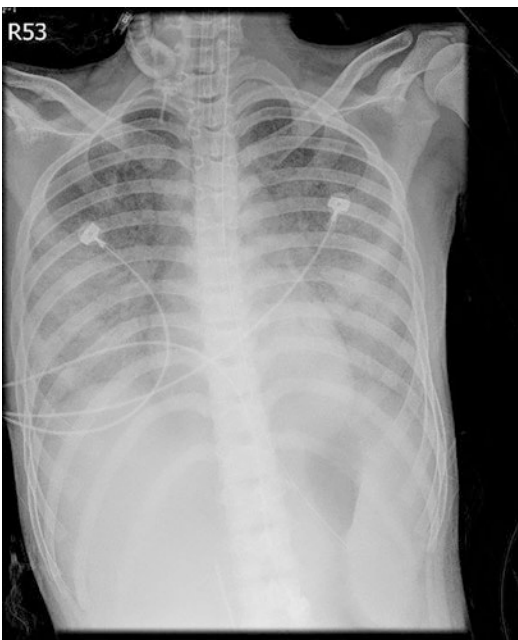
Chest X-ray taken 2 days after admission showed progression of lung lesions
